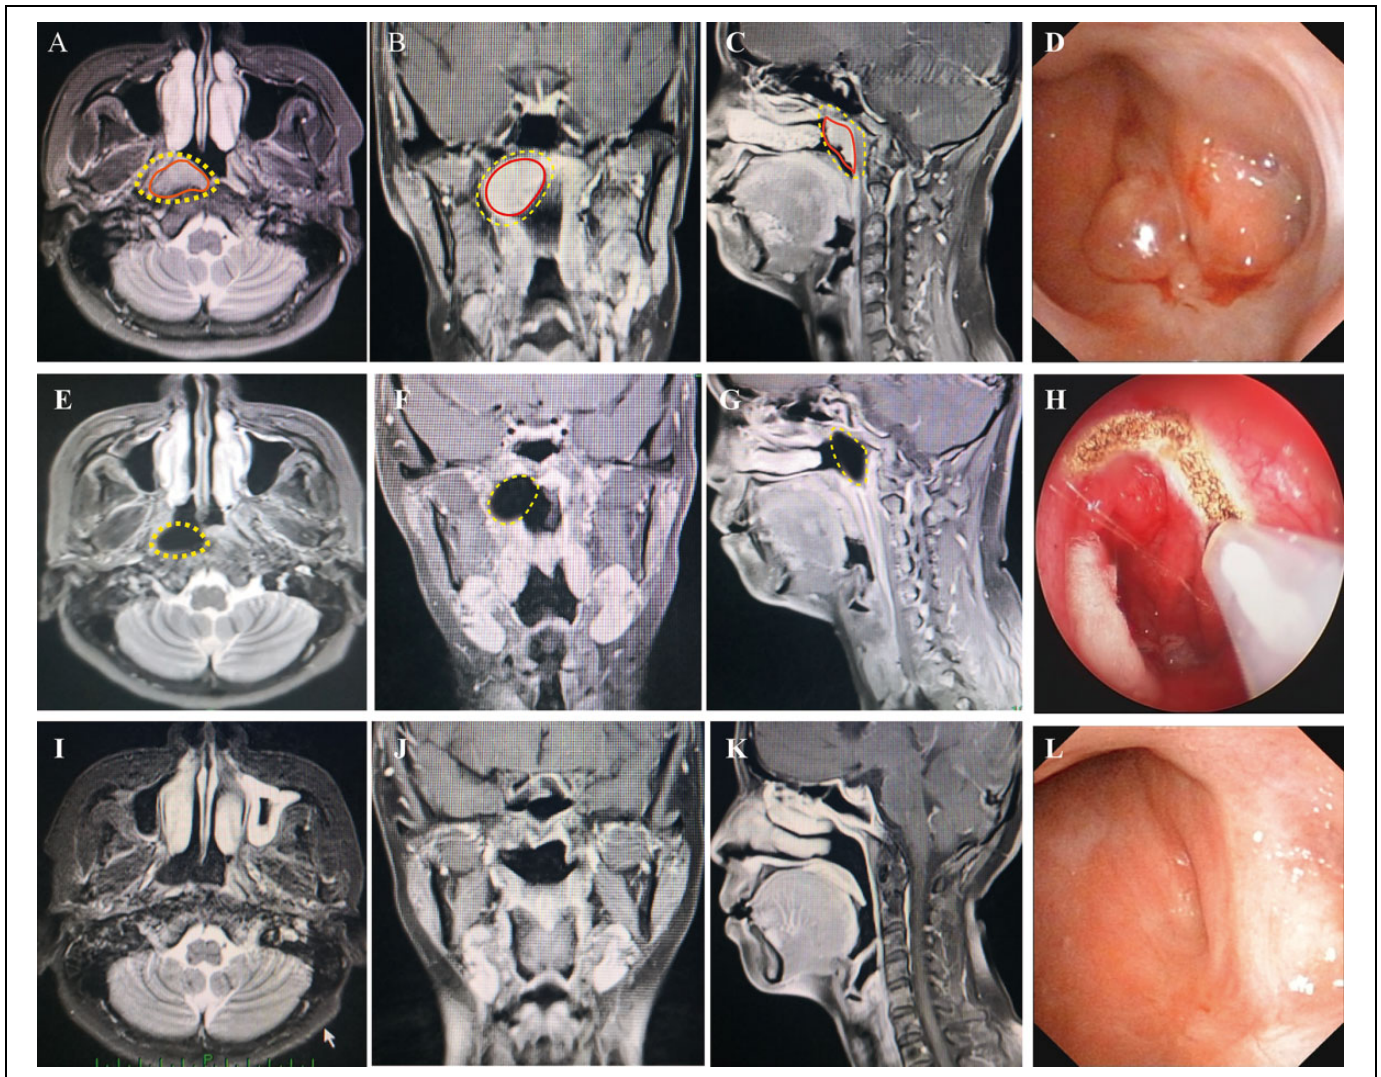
Comparisons of preoperative magnetic resonance imaging and endoscopic images to postoperative results. (A-C) T1-weighted magnetic resonance imaging in horizontal, coronal and sagittal planes showed tumor infiltration area (red line) and scope of operation (yellow line) before surgery. (D) Preoperative endoscopic image showed the tumor was in the right superior wall of the nasopharynx, which infiltrated into the bilateral pharyngeal recesses and eustachian tubes. (E-G) T1-weighted magnetic resonance imaging in horizontal, coronal and sagittal planes showed extent of surgical depletion, at 3 days after surgery. The scope of the excision is consistent with the plan (yellow line). (H) Intraoperative endoscopic image (I-K) T1-weighted magnetic resonance imaging in horizontal, coronal and sagittal planes found no signs of tumor recurrence, at 6 years after surgery. (L) Contemporaneous endoscopic image showed well epithelized nasopharyngeal mucous membrane and no signs of tumor recurrence.
